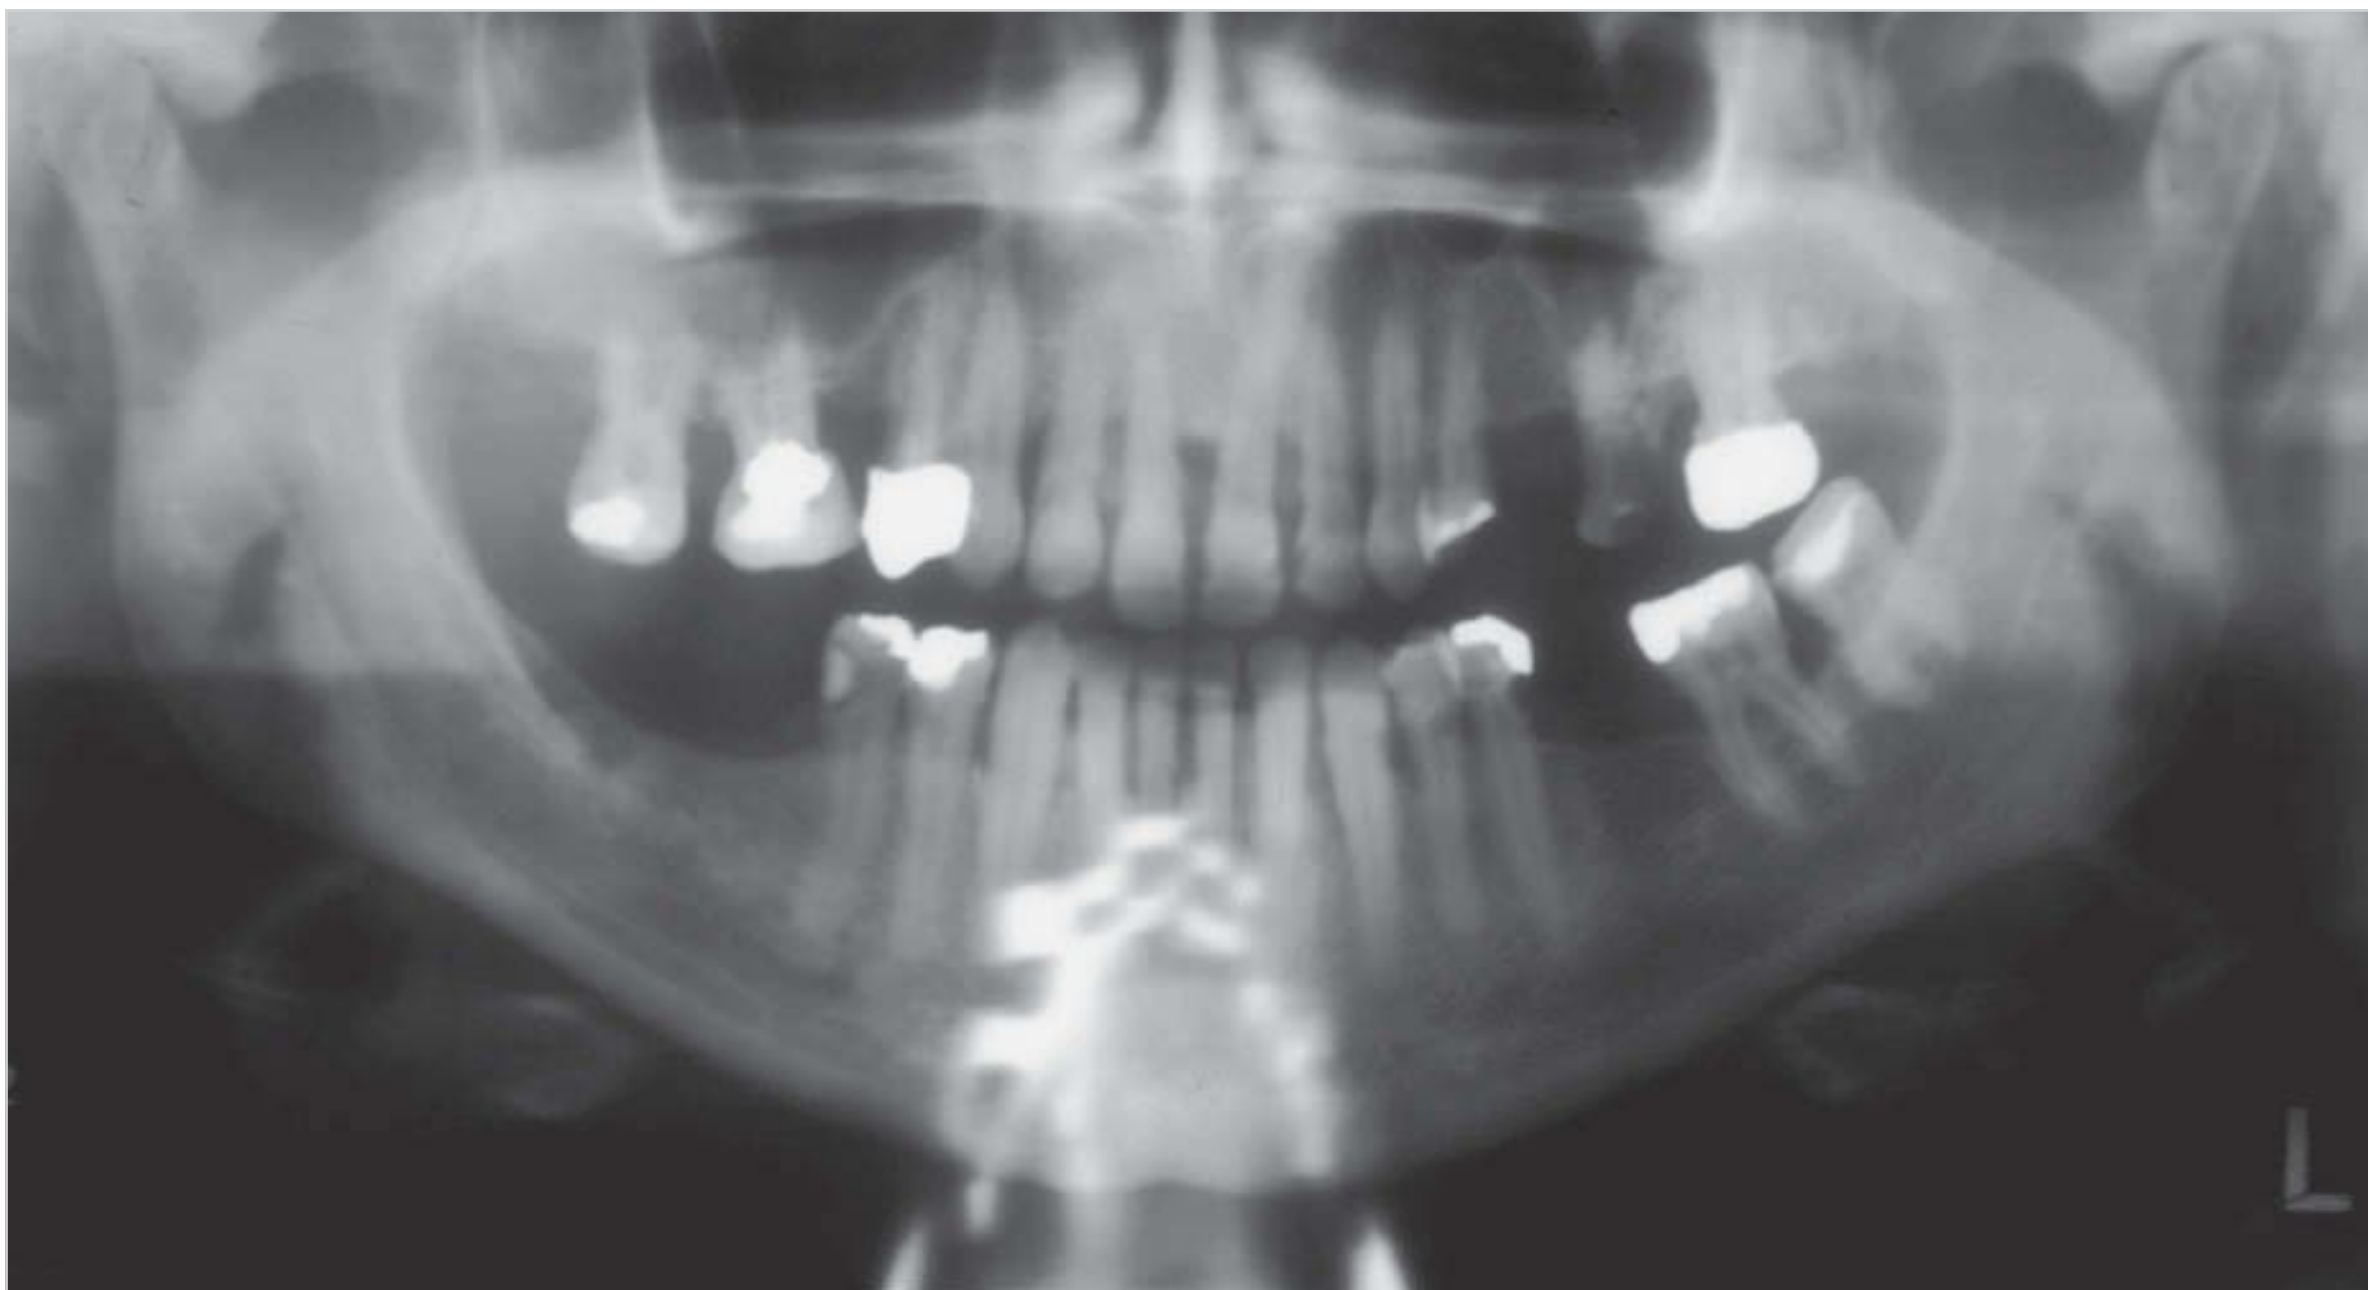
Ghost image of a necklace appearing in the anterior region of a panoramic radiograph.
